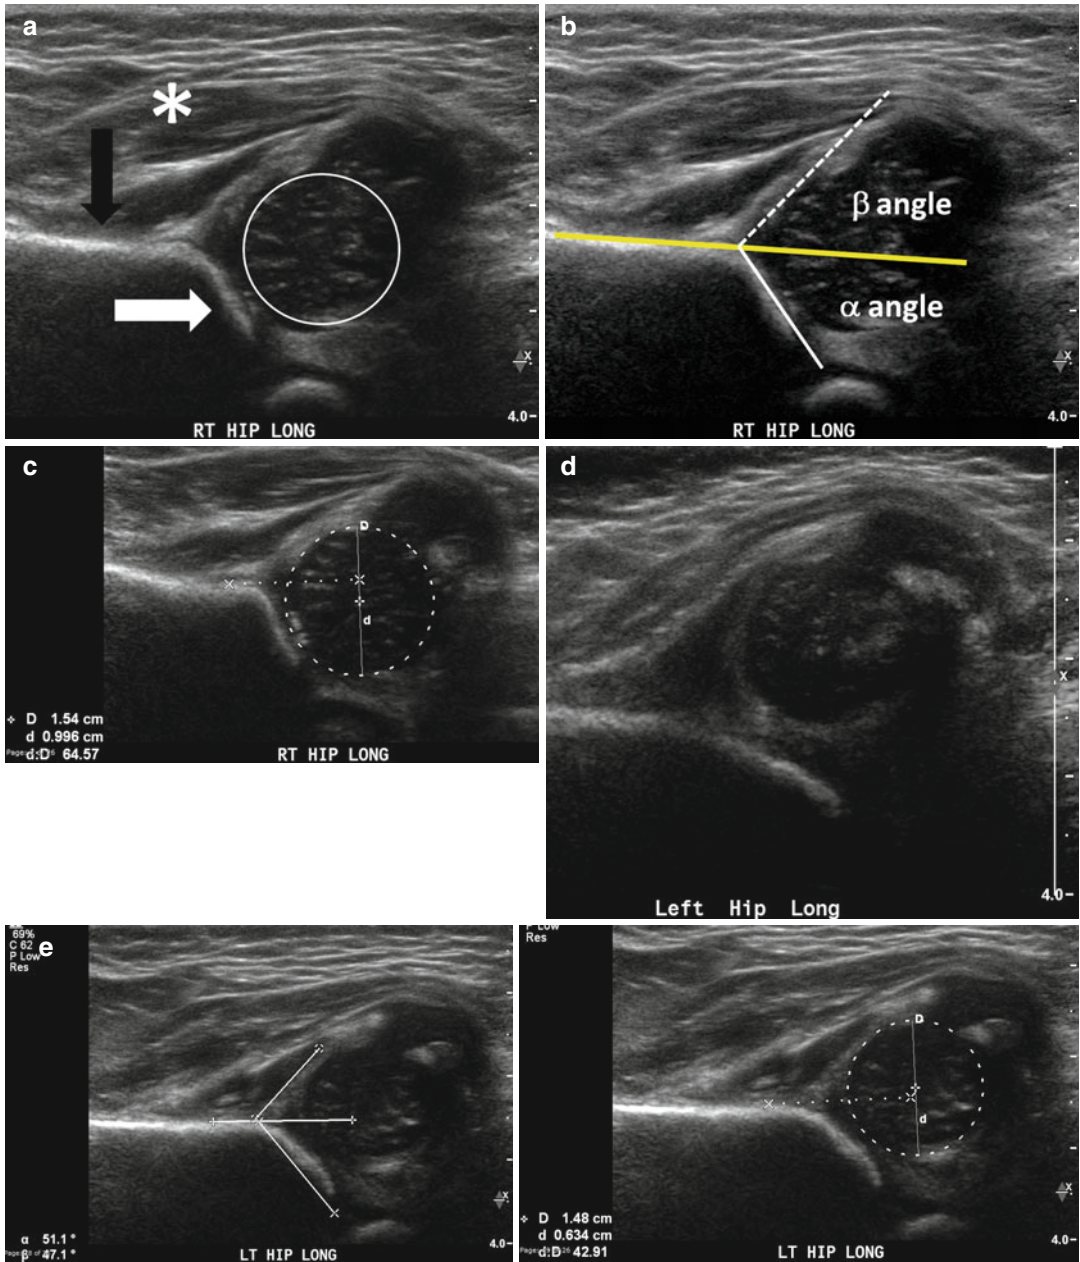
Hip ultrasounds in DDH. (a) A representative longitudinal ultrasound image of a normal neonatal hip. The ilium is marked by the *solid black arrow*, the bony acetabular roof by the *white arrow*, the abductor muscles by the *white asterisk*, and the femoral head by the *white circle*. (b) Measurement of the alpha (α) and beta (β) angles on ultrasound establish the Graf class. The baseline is first drawn and is the line along the ilium as it intersects the bony and cartilaginous portions of the acetabulum (line 1, *solid yellow line*). Line 2 (*solid white line*) is from the acetabular edge to the triradiate cartilage; line 3 (*dashed white line*) is from the acetabular
